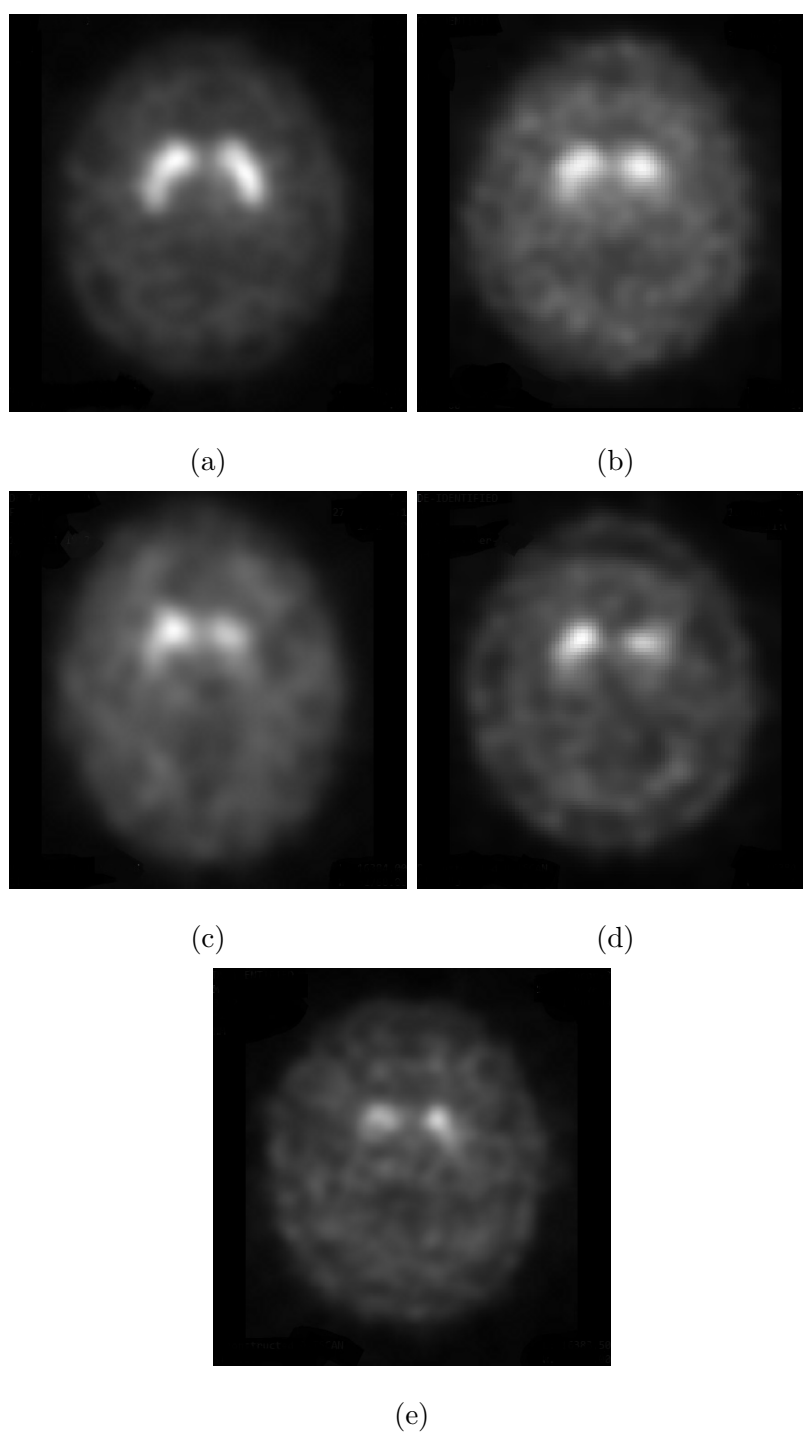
SPECT images of PD in (a) Stage 1, (b) Stage 2, (c) Stage 3, (d) Stage 4, and (e) Stage 5
